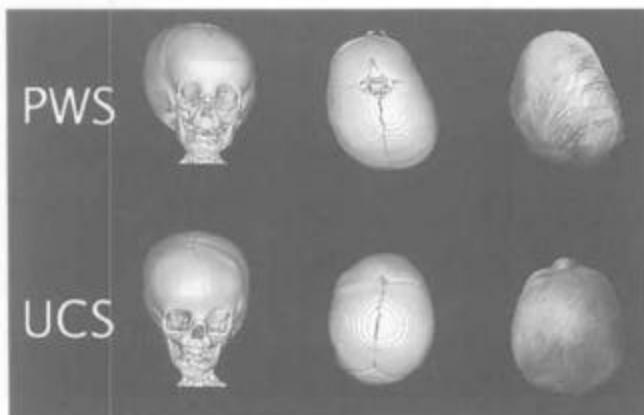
Typical 3-D CT osseous frontal and vertex images and vertex photographic appearances of PWS and UCS patients.
